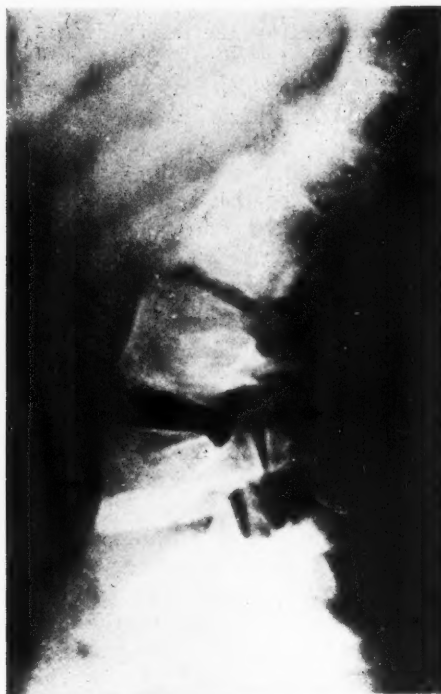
Roentgenogram of a lumbar spine, of a child seven years of age, with extreme lordosis. There is disalignment of the articulating surfaces of the facets.
